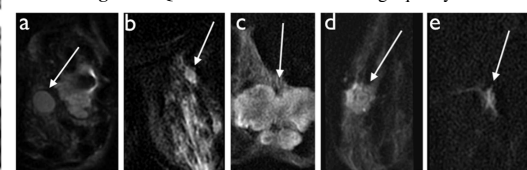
Example of round (a), oval (b), lobular (c), irregular (d) and spiculated (e) lesions on r-FOV DWI.
